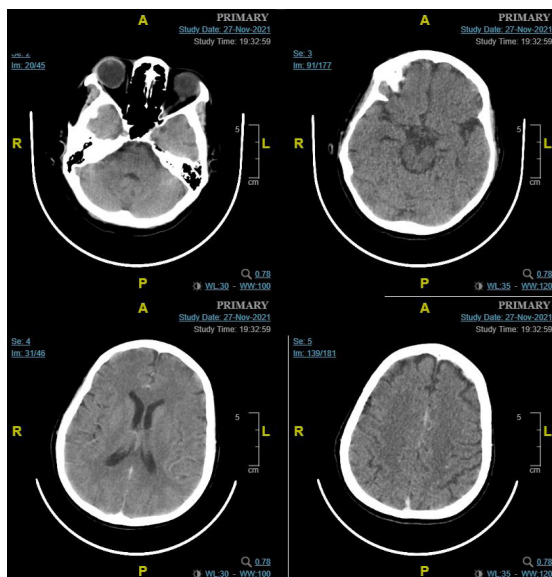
Head Computed Tomography (CT) with Contrast (Patient No. 1)
